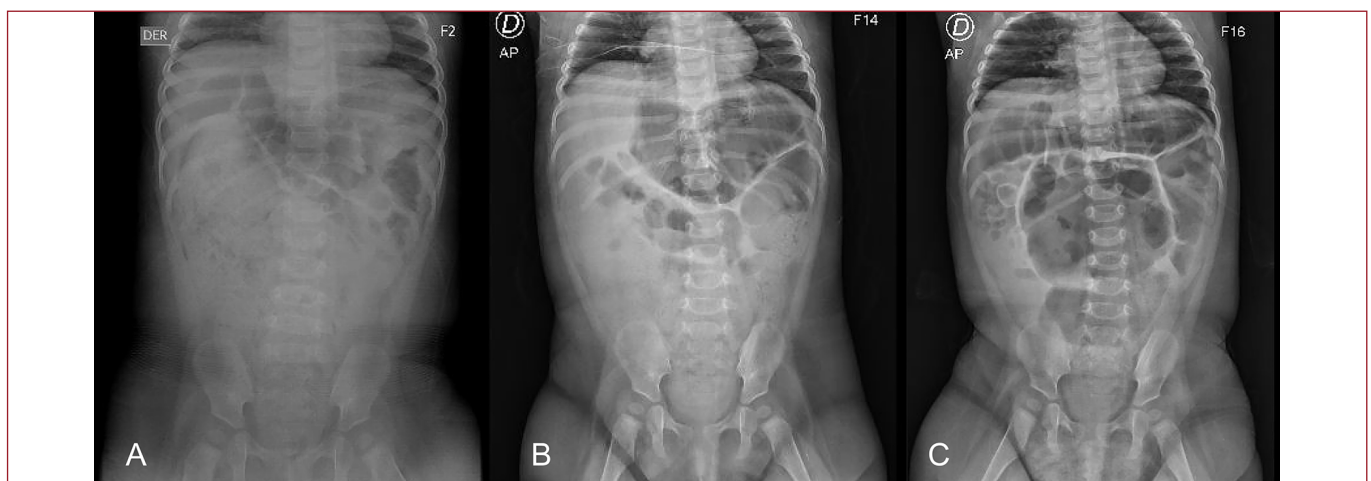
Simple abdominal radiography: A) abundant fecal matter and no air-fluid levels; B and C) control at days three and four showing fecal matter in smaller quantities and without air-fluid levels
